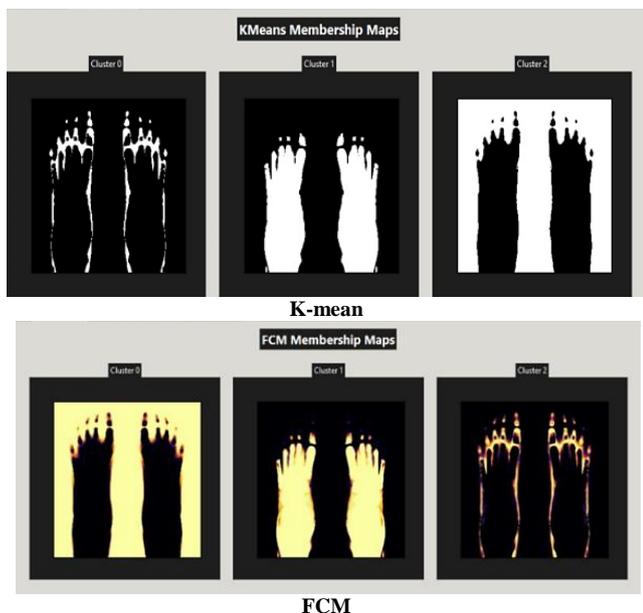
Creation of different membership maps for segmenting X-ray images using K-Means and Fuzzy C-Means clustering
